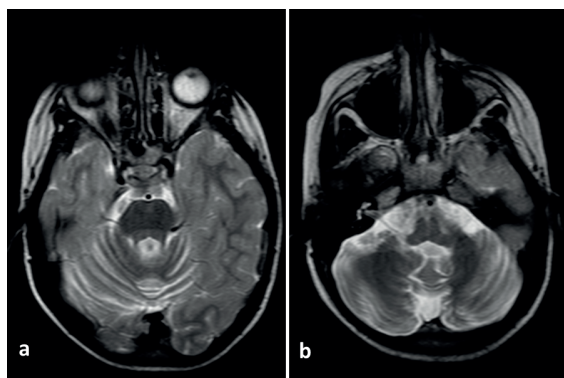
Follow-up magnetic resonance (MR) imaging at four months. Diffuse cerebellar atrophy was seen in T2-weighted axial images (a-b).
